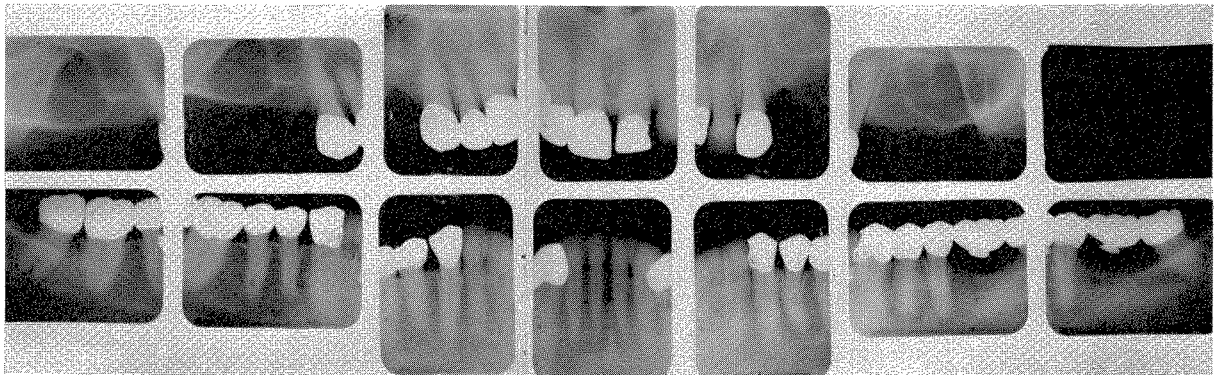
These roentgenograms were taken in November, 1954, ten years after completion of treatment.
